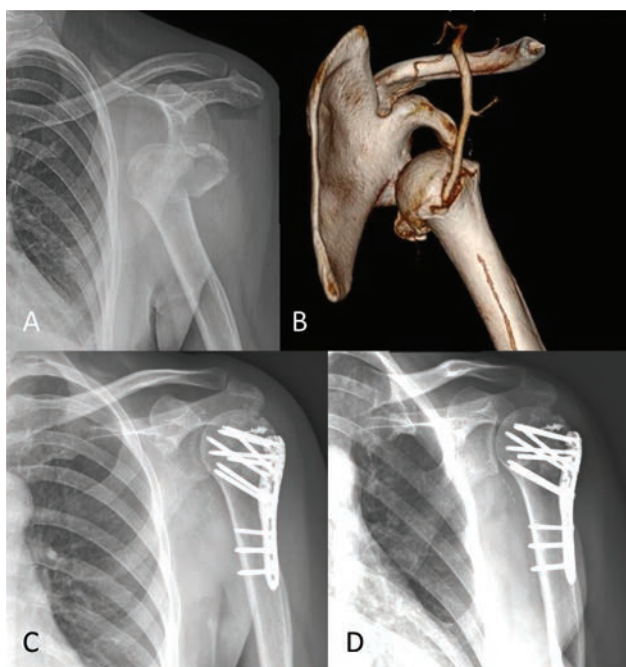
(A) Radiograph showing a fracture dislocation of a female patient whose assessment revealed an acute disturbance of circulation in the affected extremity. CT angiography (B) revealed axillary artery entrapment into the fracture site. The patient underwent open reduction immediately, vascular repair and her fracture is fixed with a proximal humerus locking plate along with an open repair of her rotator cuff tendons (C, D).
